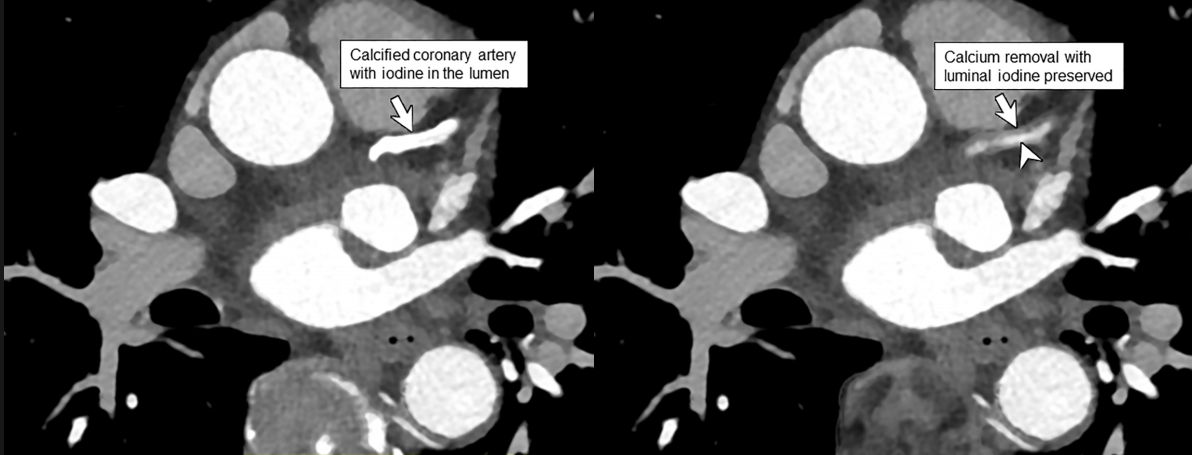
PCD-CT coronary without (A) and with multi-energy post-processing (B) using an algorithm that performs material decomposition and removes calcium signal. The post-processed image (B) shows the patent lumen adjacent to the heavily calcified plaque (arrowhead). [8]
